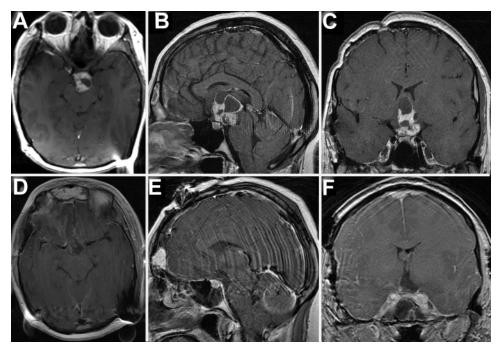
Preoperative T1-weighted MR images with addition of Gd (A, axial; B, sagittal; C, coronal views) demonstrating a large retrochiasmatic craniopharyngioma with solid and cystic components. The tumor extends superiorly to the top of the third ventricle and inferiorly into the interpeduncular cistern and retrosellar region. Postoperative T1-weighted MR images with addition of Gd (D, axial; E, sagittal; F, coronal views) showing gross-total removal of the tumor after a transbasal subfrontal approach to the lamina terminalis.
